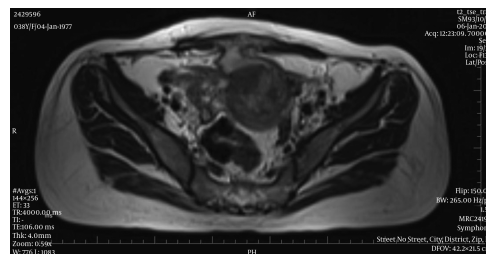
Magnetic Resonance Assessments (MRI) Indicated a Hetero- Signal Mass and Fistula in the Anterior Abdominal Wall Connecting to the Anterior Uterus (T2W- axilla view).
